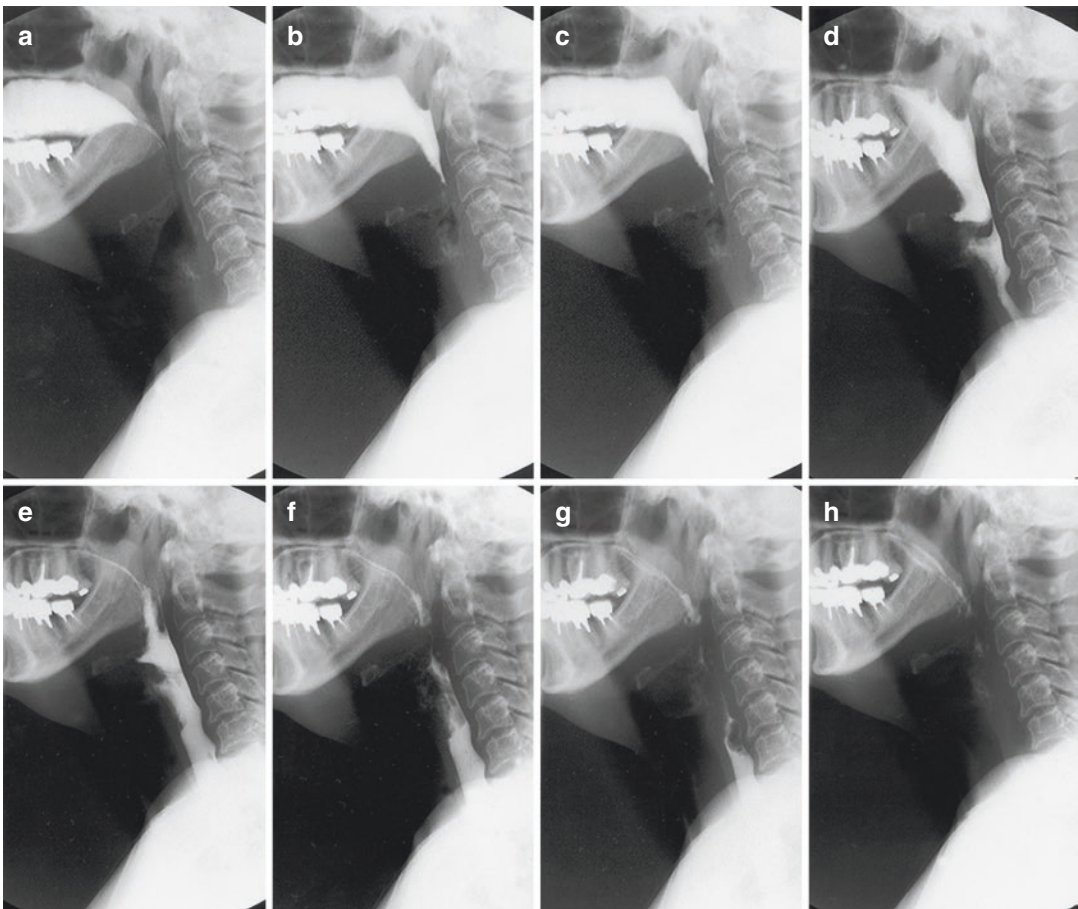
The oral, pharyngeal, and pharyngoesophageal segment (PES) stages are readily appreciated radiographically. This is a sequence of a barium swallow (a–h) in lateral projection. The bolus is gathered in the oral cavity (a–c) and is propelled into the pharynx by an upward and backward movement of the back of the tongue (d). The tilting down to a horizontal position of the epiglottis is
